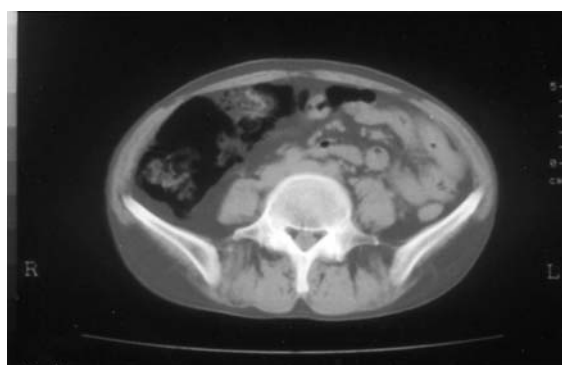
Abdominal CT scan on July 5, 2001, showing intramural gas in the small bowel
